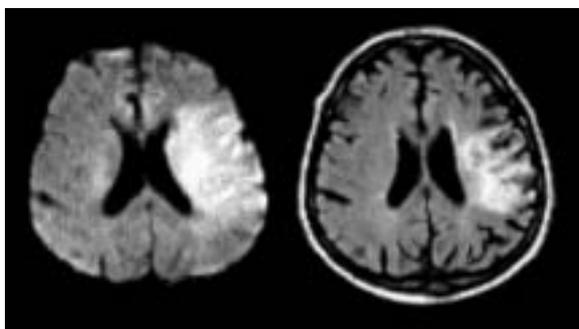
Regression of the chronic stroke lesions as visualized in a FLAIR-image four months after stroke (right) as compared with the acute DWI lesion (left).
